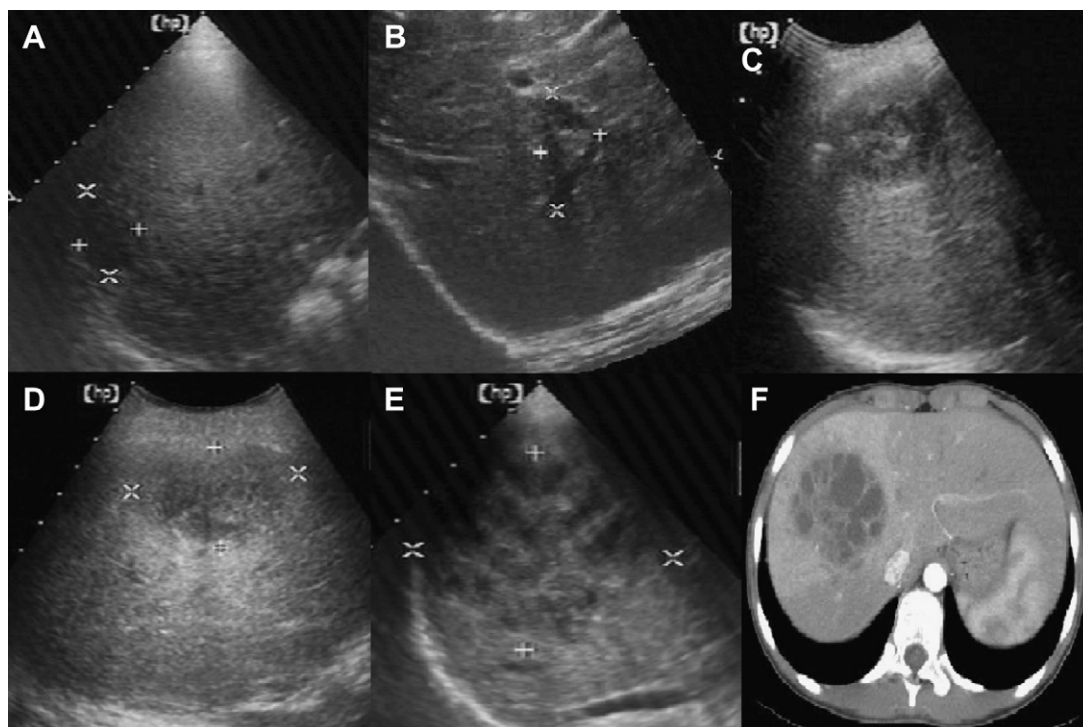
Liver abscesses: (A) Case 1; (B) Case 2; (C) Case 3; (D) Case 4; (E) Case 5; (F) Case 5, CT image.
